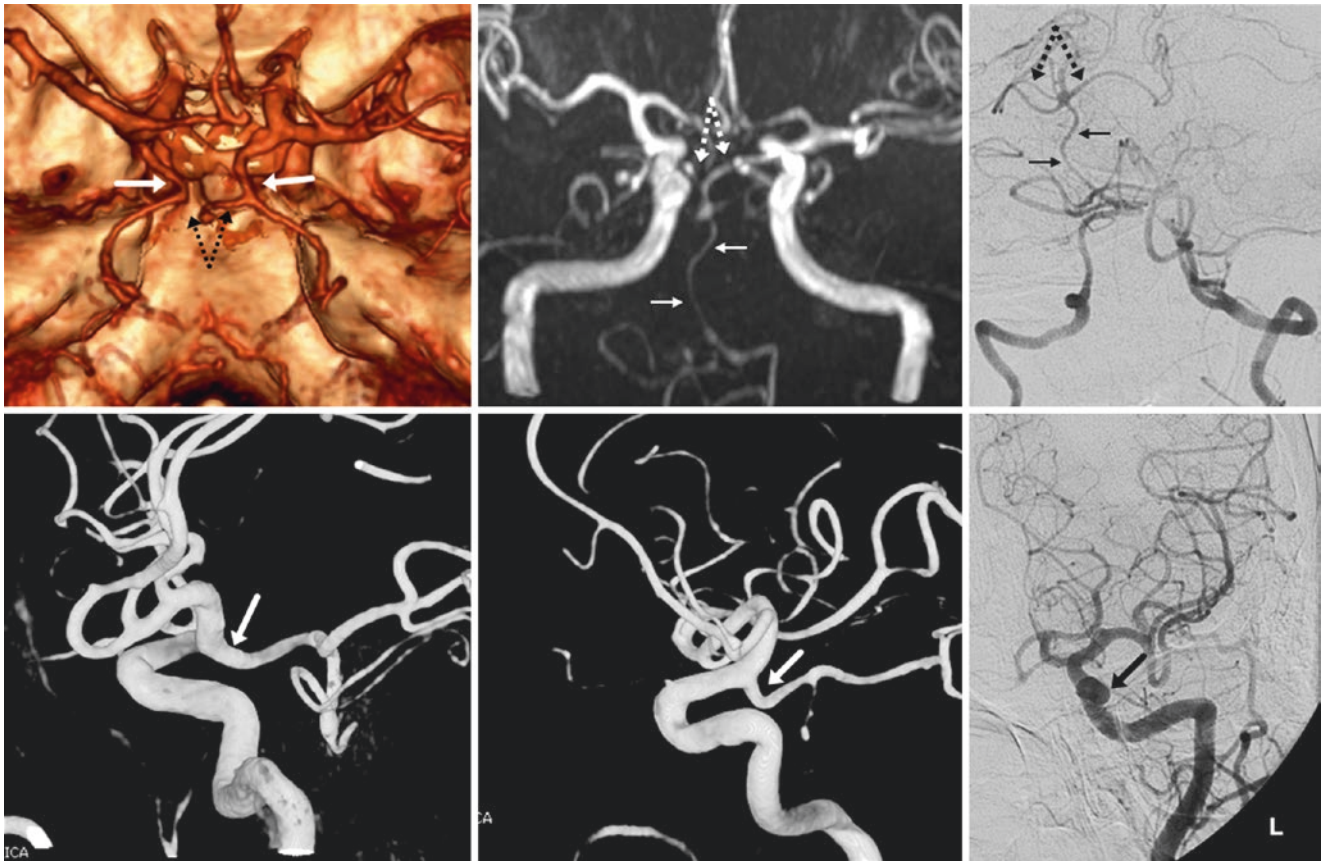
52-year-old with bilateral “fetal PCAs” (large arrows) and tiny bilateral P1 segments (dotted arrows), on a 3D VR CTA superior view (top left). The basilar was initially thought by a referring physician to have a severe stenosis, also seen on a 3DTOF MRA AP view (top
